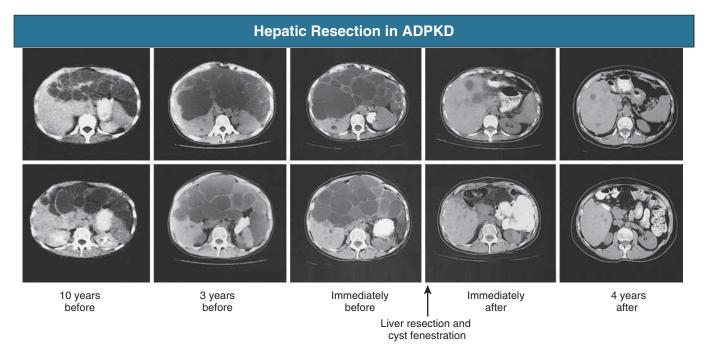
Hepatic resection in autosomal dominant polycystic kidney disease. Computed tomography scans of the abdomen 10 years before (column 1), 3 years before (column 2), immediately before (column 3), immediately after (column 4), and 4 years after (column 5) liver resection and cyst fenestration, demonstrating long-term, sustained reduction in liver size after the procedure.
